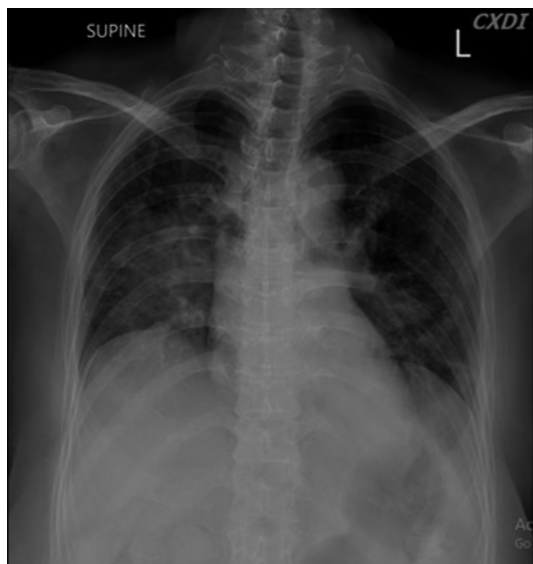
The chest radiography revealed air space opacities in bilateral lung fields, more pronounced in the right perihilar regions.
